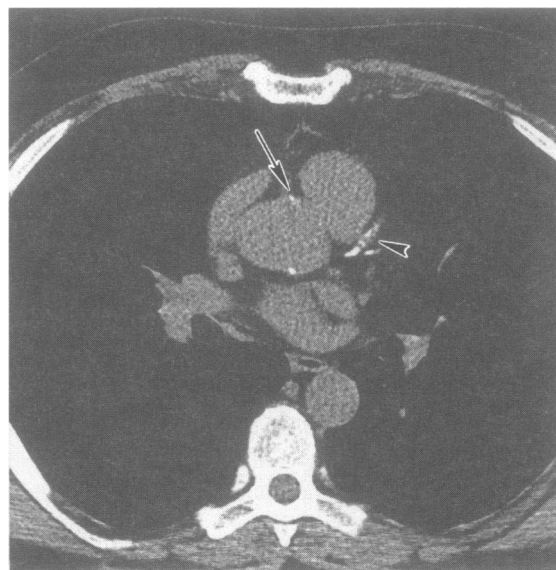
Electron beam computed tomographic scan showing calcification in the mid-portion of the left anterior descending coronary artery (arrowhead) and ostium of the right coronary artery (arrow)
